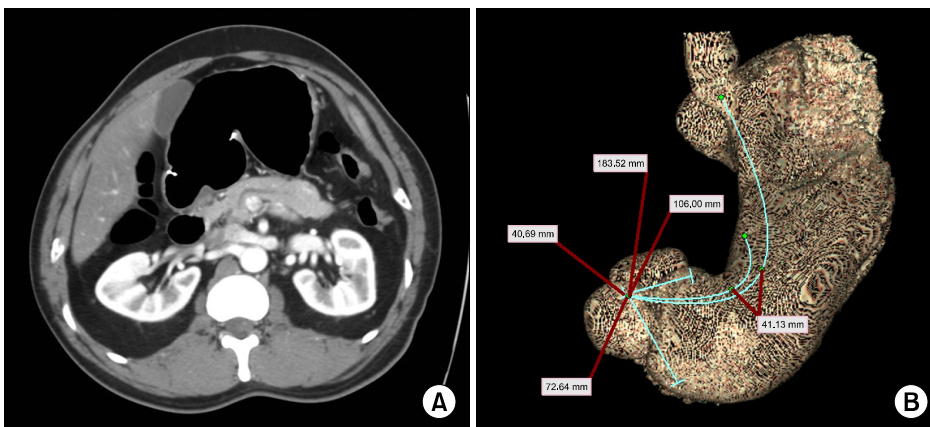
Preoperative measurements using a computed tomography (CT) scan. The endoscopic clips were readily detected by CT scans (A), which allowed the 3-dimensional image to be reconstructed. Distances between the pylorus and the clip proximal to the tumor, the angle clip, the clip placed opposite the angle on the greater curvature, and the gastroesophageal junction were measured (B).
